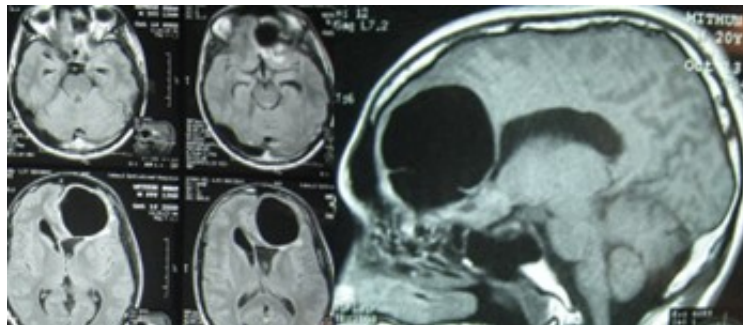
MRI of the brain: axial FLAIR images (left side) and T1W sagittal image (right side) showing post-head injury frontal tension pneumocephalus (with CSF rhinorrhea through ethmoid sinus). Source: Figure by authors.
